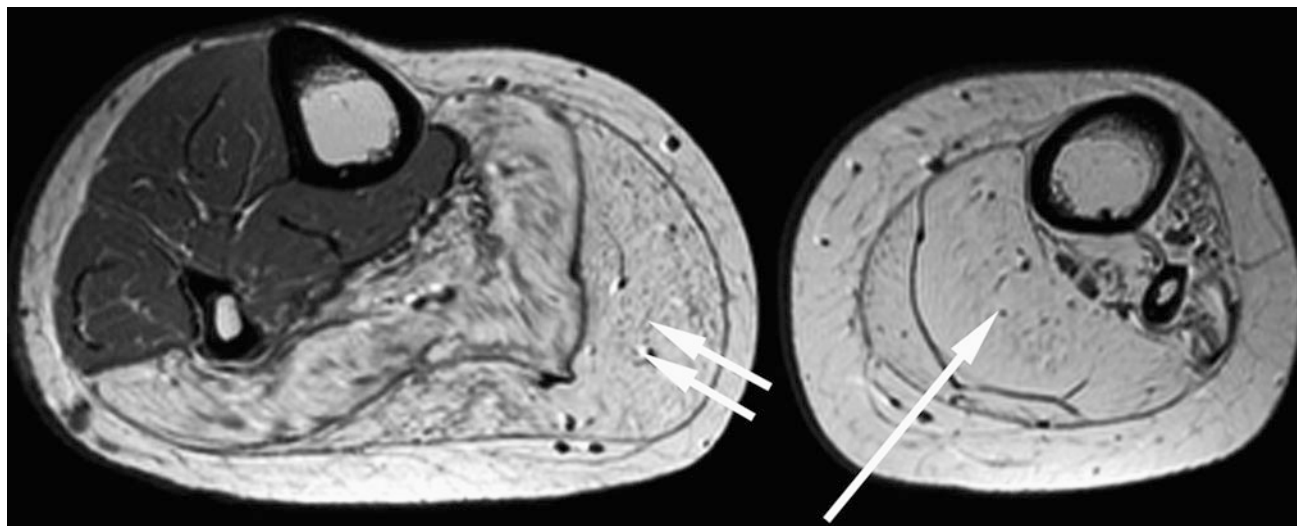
Severe neurogenic fatty atrophy in the chronic stage after motor neuron disease. In this patient long-standing weakness predominantly of left lower leg was caused by poliomyelitis during childhood. Correspondingly, T1-weighted muscle MRI without fat-saturation shows complete substitution of muscle tissue with fat (*right image with single white arrow* pointing on left lower leg with nearly
